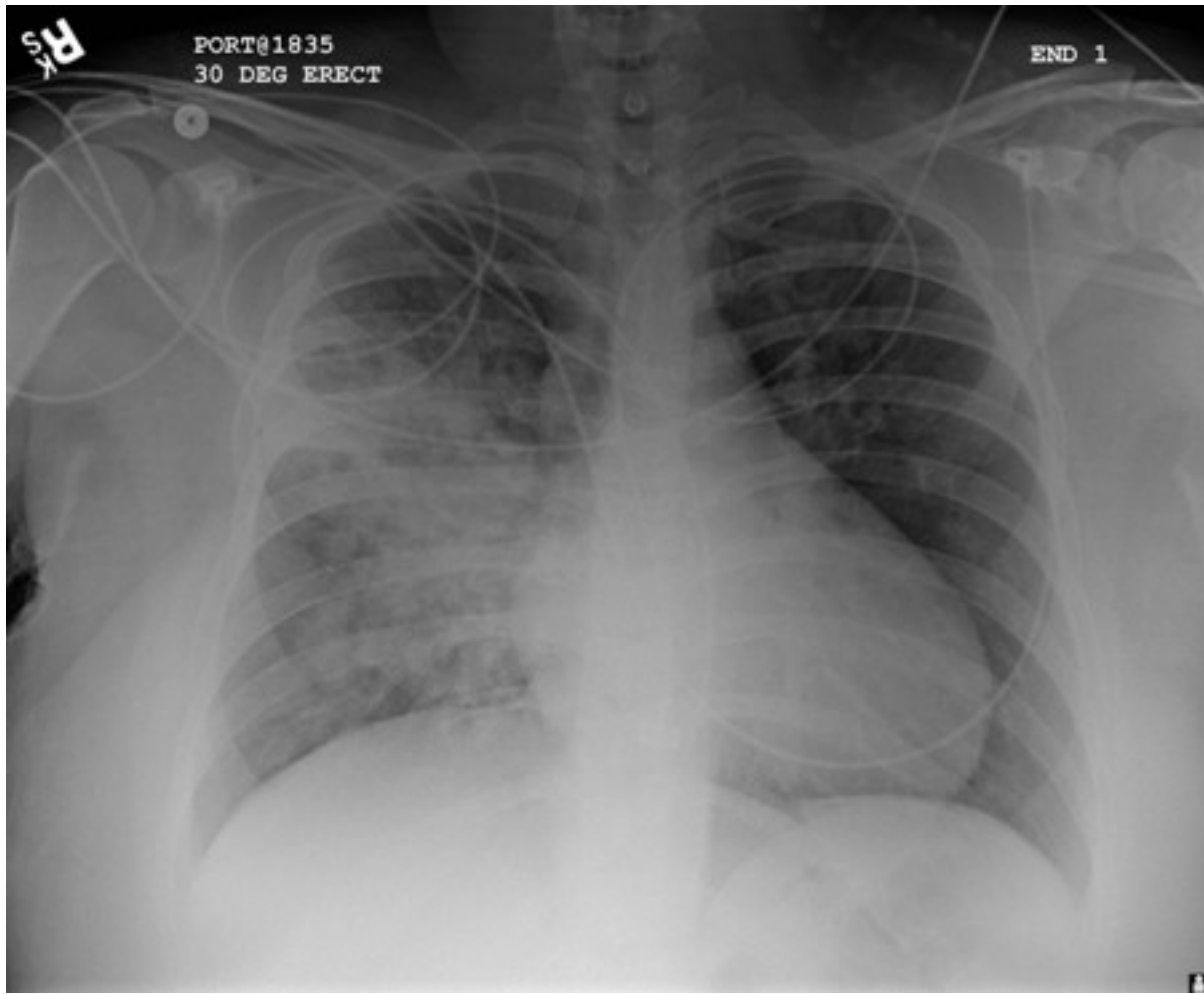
Chest x-ray with lack of normal tapering producing a tram line in a patient with bronchiectasis*
